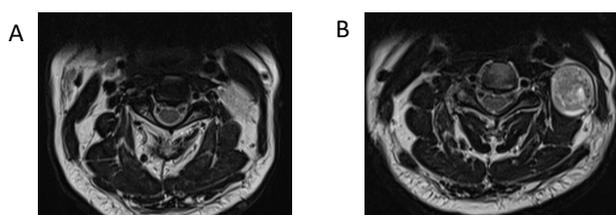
MRI neck axial view showing a hyperintense mass on T2-weighted, which was located deep to the SCM muscle (A), and a beak-like configuration was seen pointing towards the left C2/C3 neural foramen (B).
